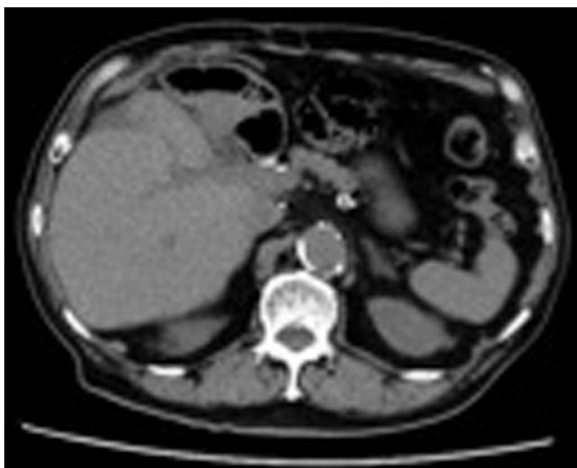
No liver abscess or accumulation of gas was detected in the abdominal CT scan made after 8 months.
